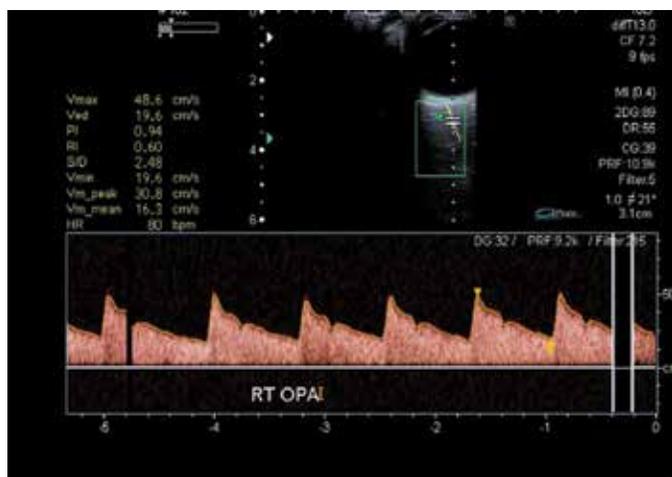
Color Doppler Imaging of Ophthalmic Artery and characteristic waveform
